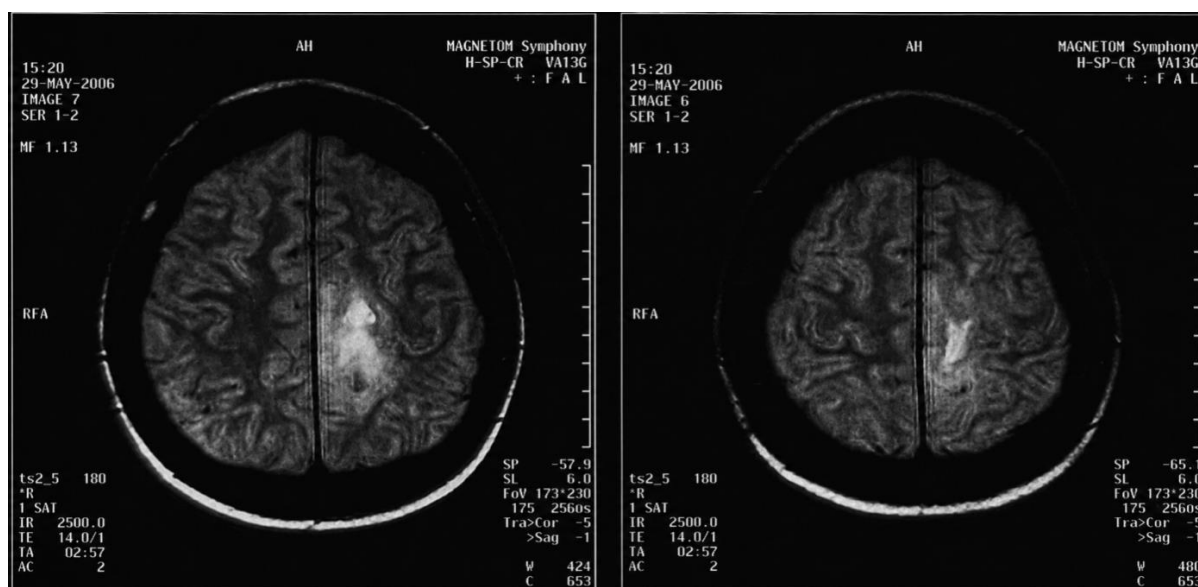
MRI sections of the same brain tumor acquired at different levels taken at the time of the beginning of the second period's second stage (29 May 2006).
